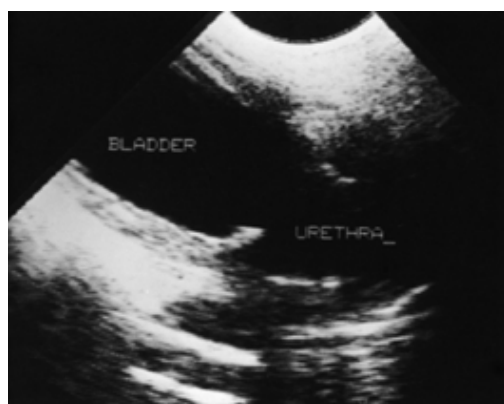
Suprapubic ultrasound demonstrating dilated bladder and posterior urethra strongly suggestive of posterior urethral valves.
